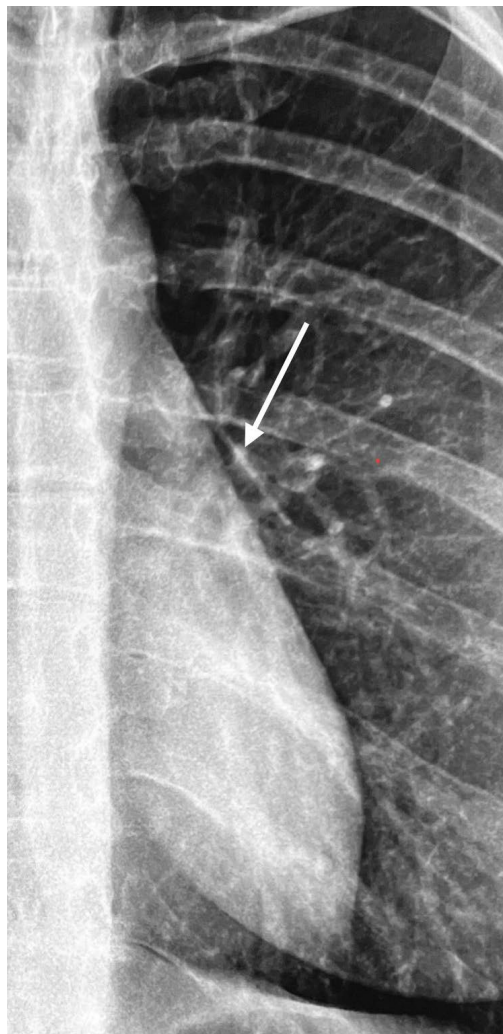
Chest X-ray image showing implant in the left lung.
